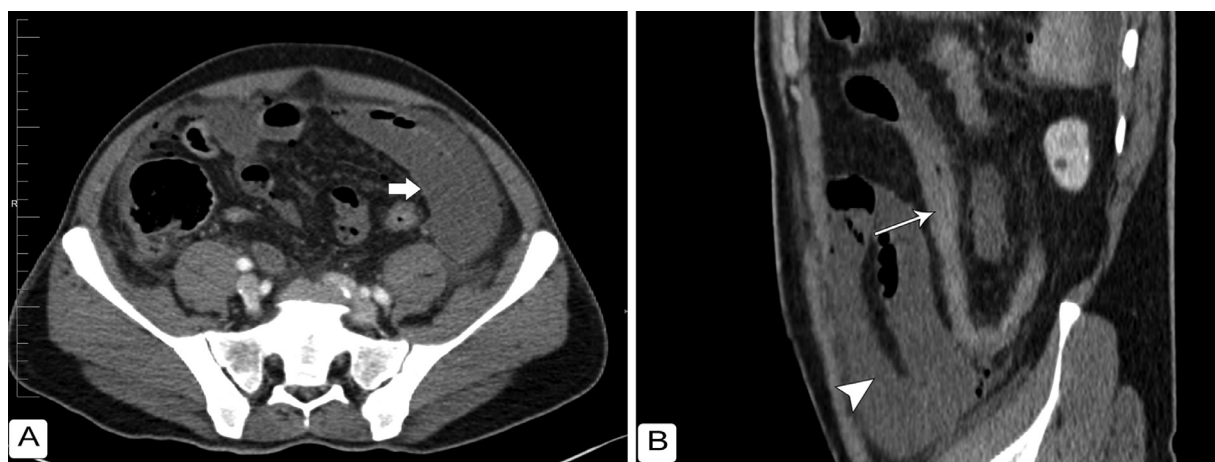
(A) Contrast enhanced CT of the abdomen in axial section showing dilated small bowel loops with non-enhancing walls (arrow). (B) Contrast enhanced CT of the abdomen in sagittal section showing dilated, non-enhancing bowel loops (arrowhead), in comparison to normal caliber bowel with enhancing walls [long arrow].
